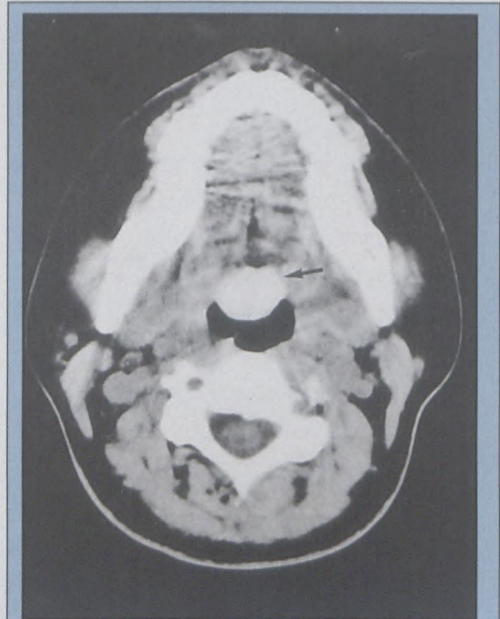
Axial unenhanced CT scan showing a homogenous hyperdense lobular mass at the base of the tongue (arrow).
